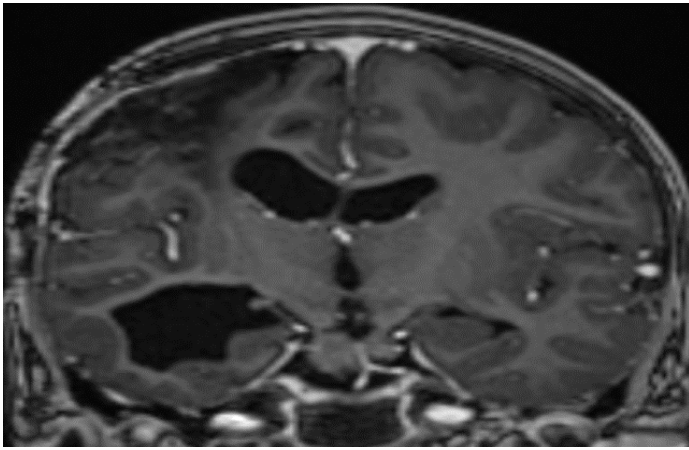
Follow up gadolinium-enhanced MRI brain T1-weighted image in coronal view after treatment completion shows right frontal encephalomalacia with cystic ex-vacuo dilatation of the right lateral ventricles as well as resolved right frontal rim enhancing lesions and mass effect.
